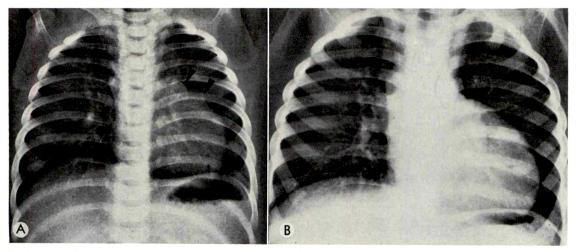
(A) Chest roentgenogram at 6 months of age demonstrates a heart which is mildly enlarged and prominent on the left with two convexities (arrows) along the left upper heart border probably representing lateral margins of the right (more cephalad) and left atrial appendages. (B) At 2 years of age the heart is relatively larger projecting mainly to the left. Note the flat inconspicuous margin of the right atrium along the lower right heart border.
